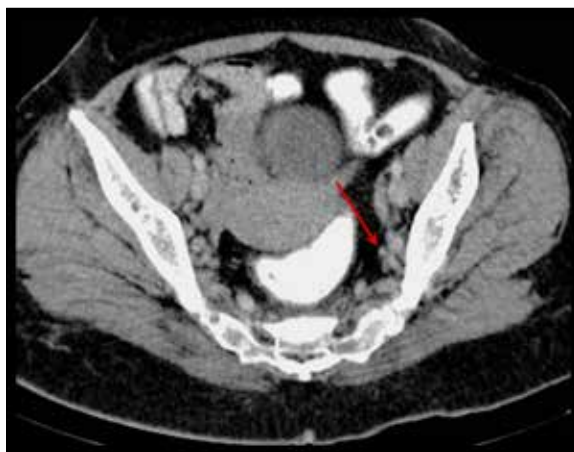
Contrast-enhanced CT scan of the lower abdomen shows multiple subcentimeter internal iliac lymph nodes (red arrow).
